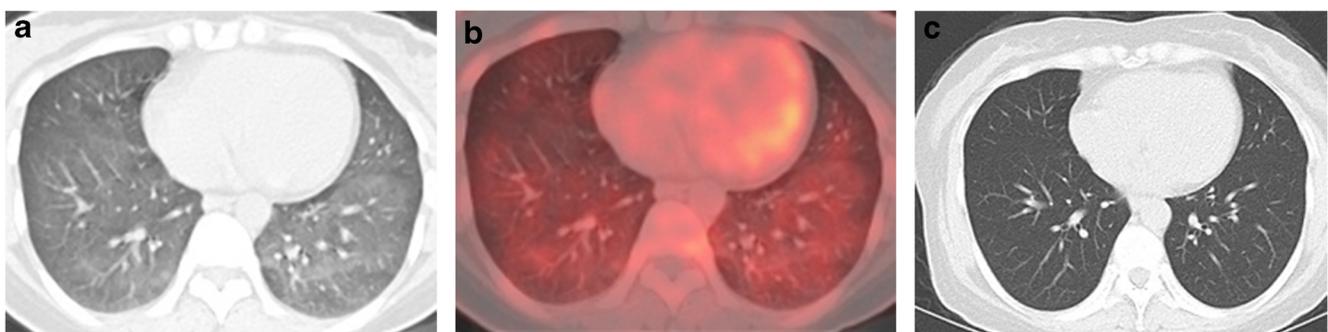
PET/CT and chest CT scans for a 46-year-old woman with DLBCL. She had cough and dyspnea after four courses of R-CHOP. ^{18}F -FDG-PET/CT suggested diffuse distribution of ground glass shadows with increased FDG uptake (SUV_{max} 2.24). Drug-induced lung injury
